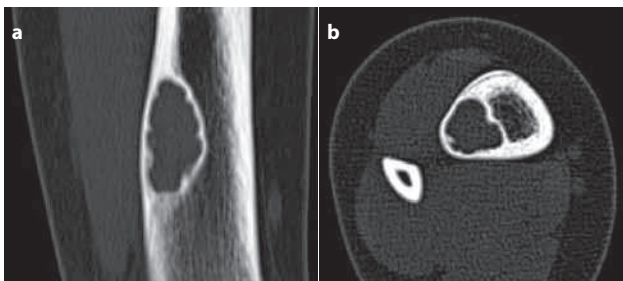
Coronal and axial computed tomography (CT) view of distal right tibia: An eccentric cortical lesion with sclerotic margins, internal cortical scalloping. No periosteal reaction or cortical lysis is observed.
